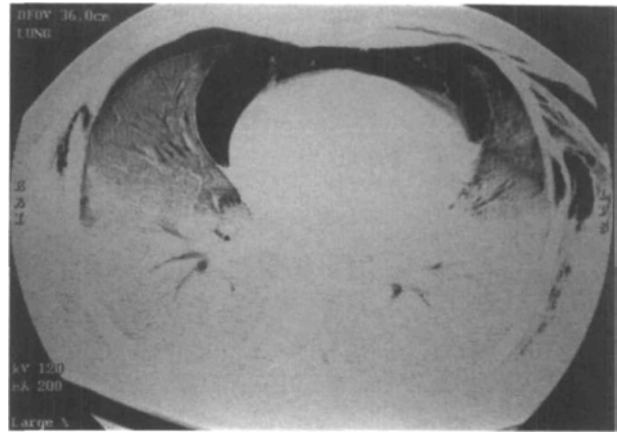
Case report #1: CT scan after admission to a major trauma centre. Homogenous opacification of both lungs with ventro-dorsal gradient representing acute lung-injury combined with pneumothorax and pneumomediastinum on both sides.
